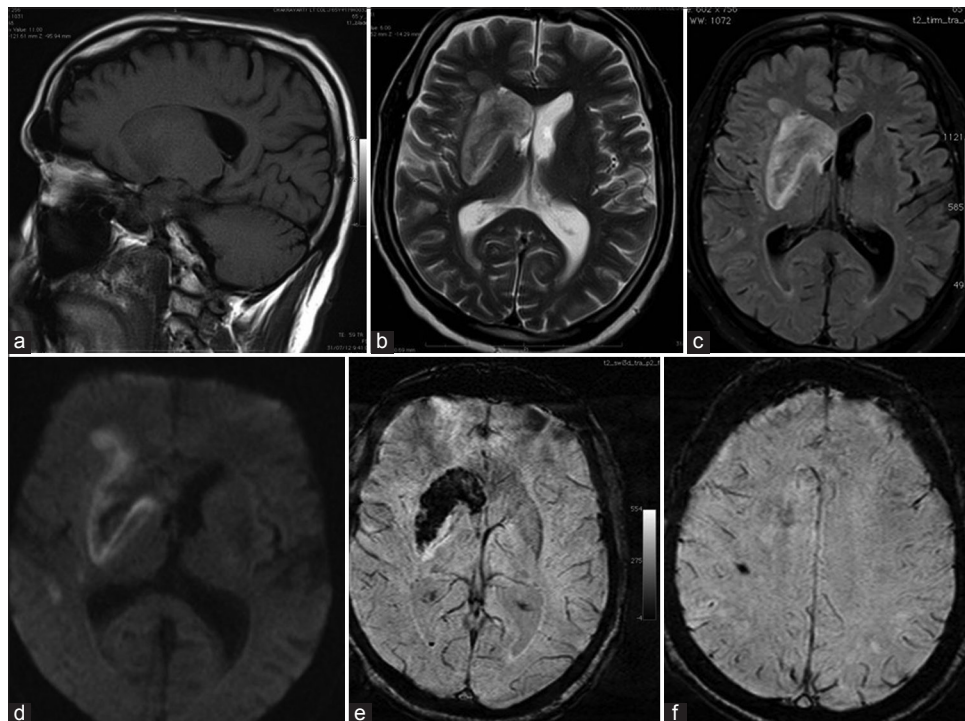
(a-f) T2 weighted and FLAIR sequence image showing heterogeneous lesion in the right basal ganglia with diffusion restriction. Susceptibility-weighted imaging shows hypointense blooming area in the right basal ganglia suggestive of hemorrhage
